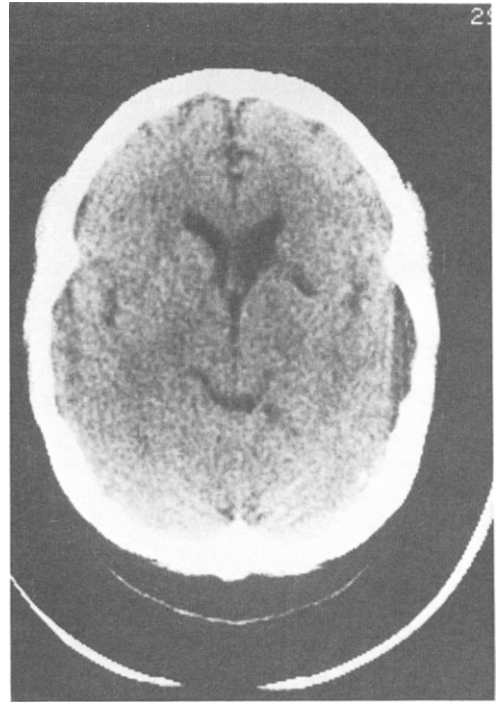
CT scan obtained 1 month after the initial scan. Evidence of an old infarction within the head of the left caudate nucleus is seen. Some increased prominence of the left lateral ventricle as well as a small area of encephalomalacia are also visualized.
